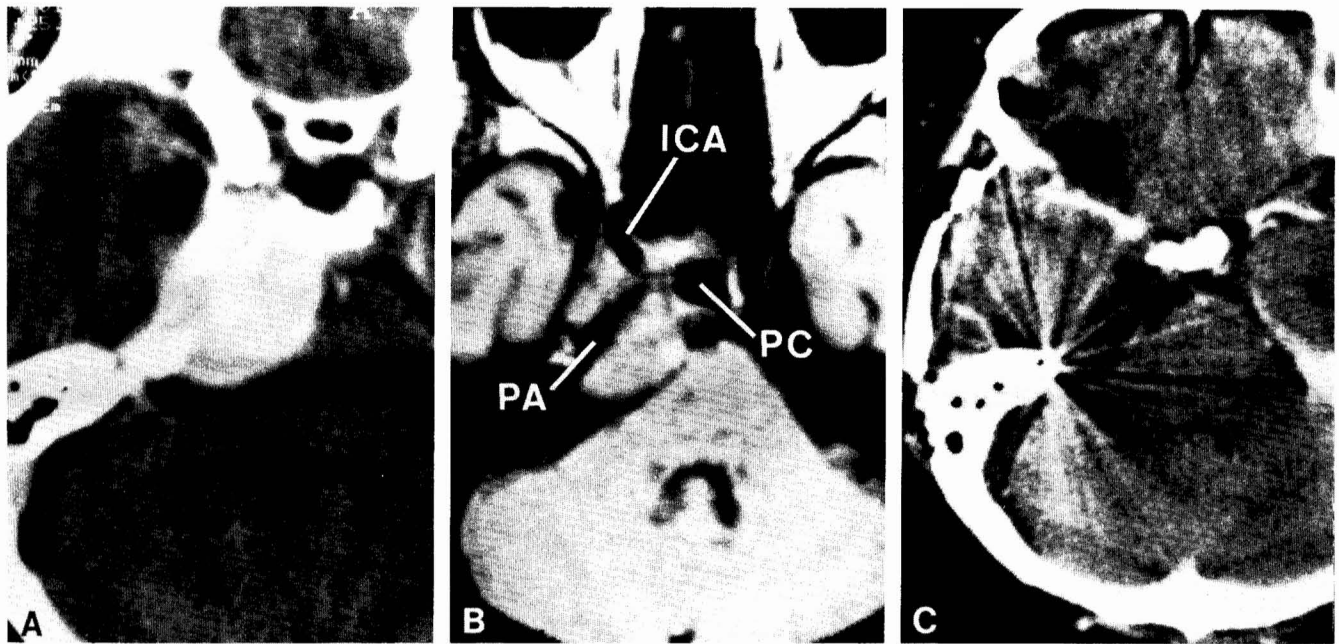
Case 3. A, CT scan before surgery. B, MRI scan of the same section. The locations of the carotid artery (ICA) and petrous apex (PA) are clearly shown. PC, posterior clinoid. C, CT scan taken 14 days after surgery. The tumor has been totally removed.
